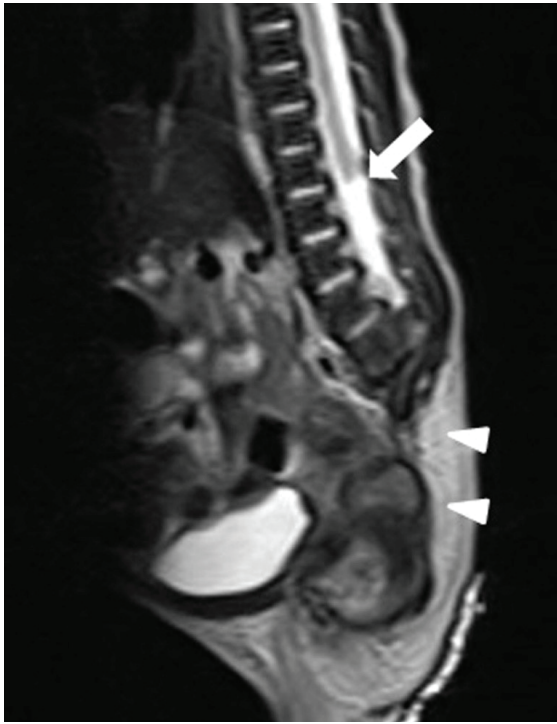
MRI scan of the sagittal plan. The conus medullaris was absent and the spinal cord was ending abruptly at the level of the L2 vertebrae corpus (thin arrow). The sacral vertebrae were also absent (thick arrow).
